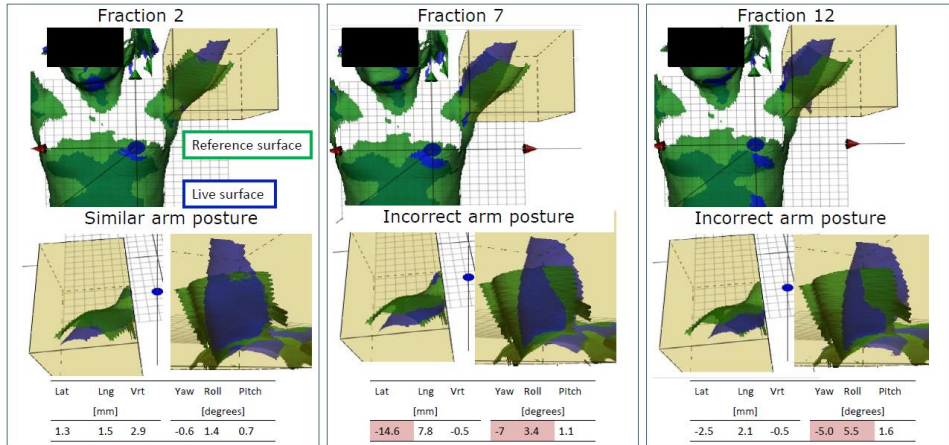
The arm posture variation for patient 31. The surfaces from treatment (blue) have been registered to the reference surface (green) acquired at CT. The numbers in the bottom is the shift that brings the surface of the arm at treatment to the surface of the arm at CT. Incorrect arm posture was identified using these numbers and by visual inspection of the surfaces. Visual inspection was needed as the registration was limited to a small surface area with few features and hence the registration results were not stable. Shifts > 5 mm (in either lat, lng, vrt) or > 3 degrees (in either yaw, roll, pitch) are high-lighted in red.
